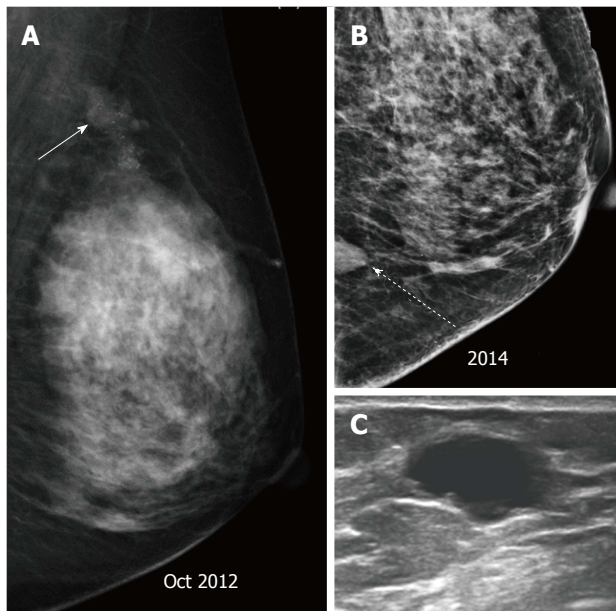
Patient with a left breast mass (arrow), who underwent breast-conserving therapy (A), (B) follow up mammogram at 2 years revealed a neodensity (dashed arrow) which on ultrasound (C) was found to be a cyst.
